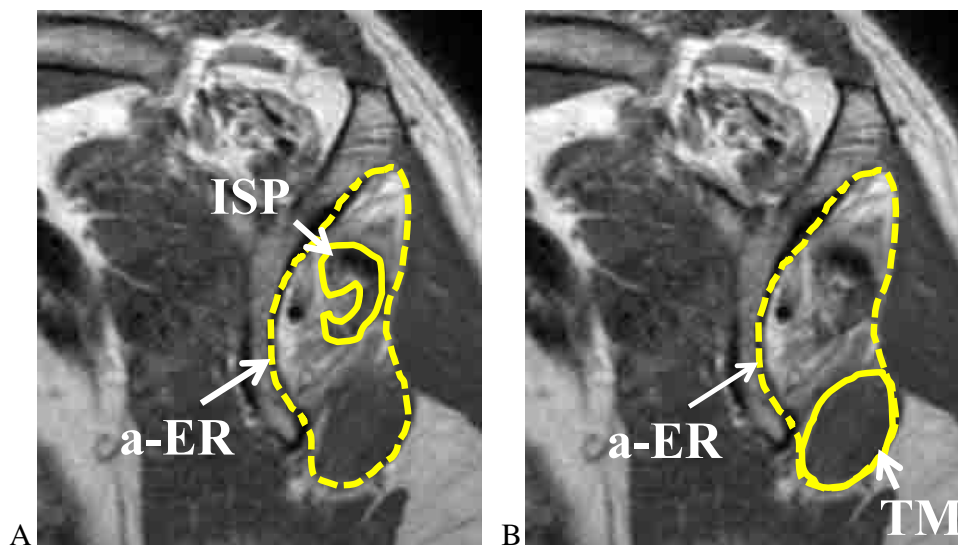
The area of infraspinatus (ISP), teres minor (TM), and the anatomic external rotator (a-ER) muscles on the most lateral oblique sagittal magnetic resonance image in which the scapular spine was in contact with the scapular body. The a-ER muscle area was traced on the lateral margin of the scapula, the inferior margin of the TM muscle, and the medial margin of the deltoid. (A) The occupational ratio of ISP muscle = the area of ISP muscle/the area of a-ER muscle, and (B) the occupational ratio of TM muscle = the area of TM muscle/the area of a-ER muscle.
